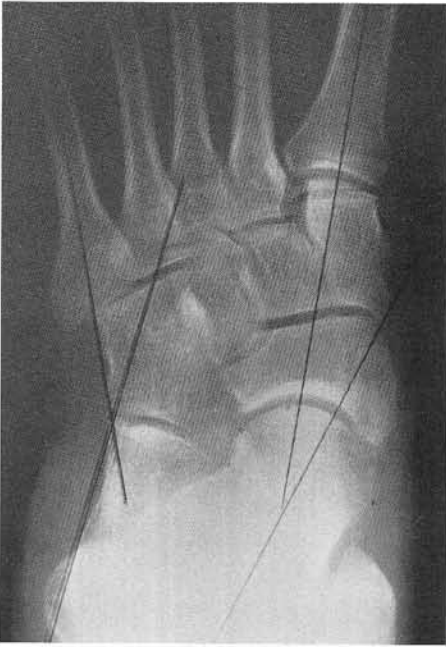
Dorsoplantar weight-bearing radiograph of a patient with an adult acquired flatfoot syndrome secondary to long-standing tibialis posterior tendon dysfunction. Note the degree of peritalar subluxation indicative of pronation. The lines shown are used to determine radiographic parameters.
